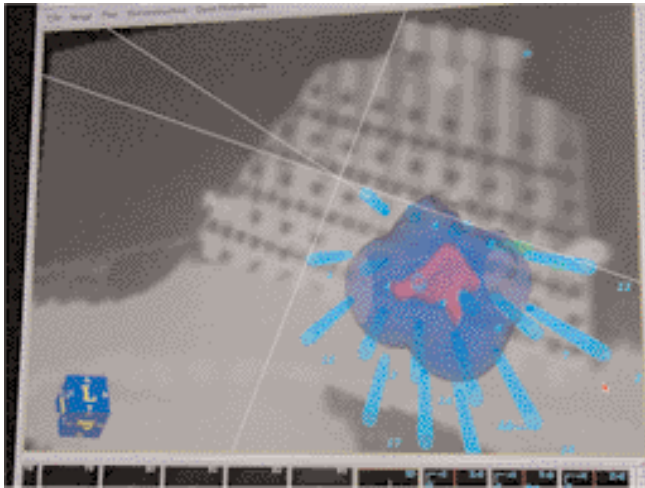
Interstitial multicatheter breast brachytherapy using CT-guidance and a special breast template
